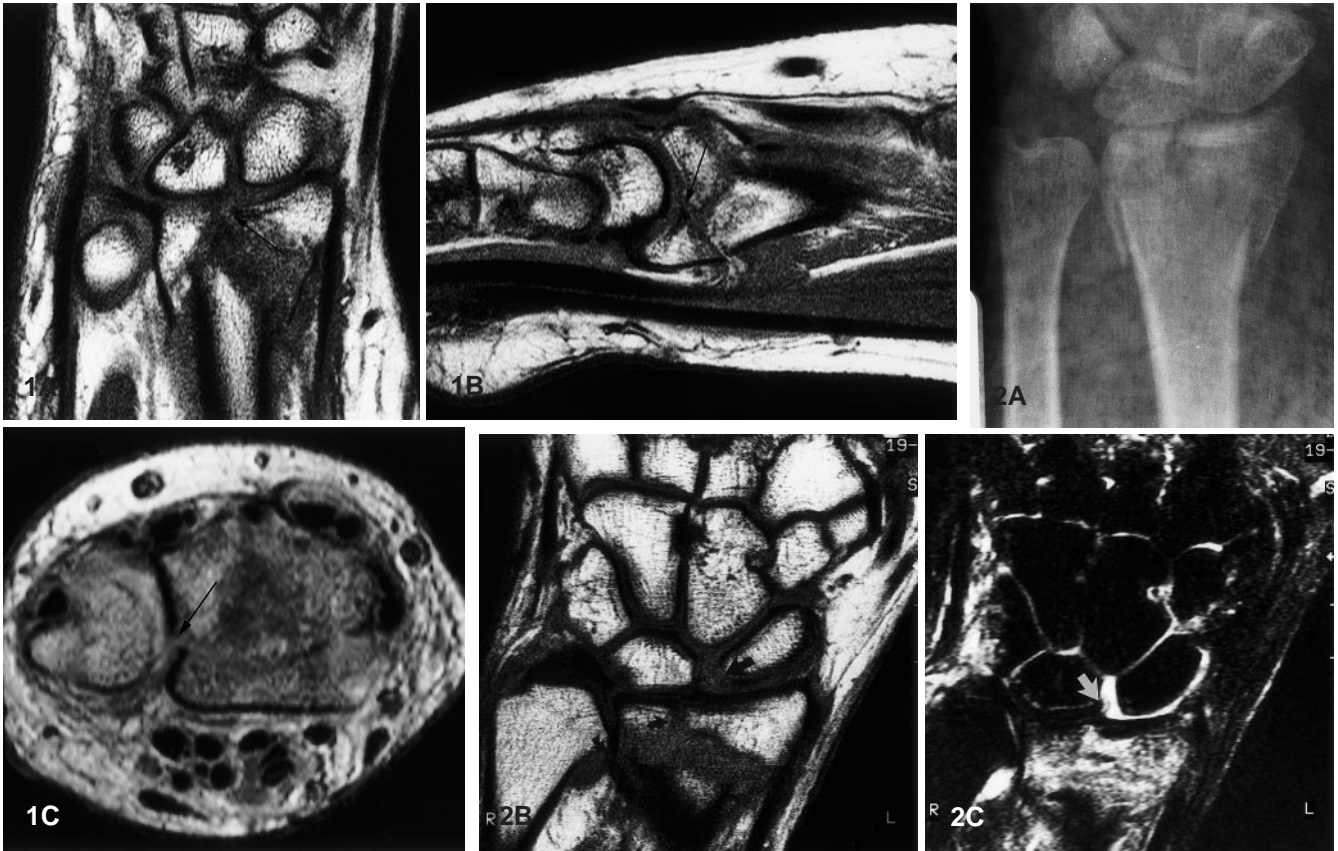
A Coronal T1-weighted SE image (TE 15, TR 500) shows a comminuted impaction fracture of the distal radius, with intra-articular extension to the junction of the scaphoid and lunate facets (*arrow*). B Sagittal image shows impaction, and intra-articular extension (*arrow*) with neutral angulation. C Axial image shows undisplaced intra-articular fracture to the distal radioulnar joint (*arrow*)
